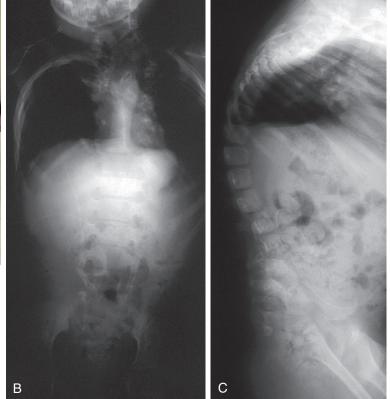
Spina bifida. A, This child with thoracic-level spina bifida has an obvious kyphotic deformity. The scars on her back are from surgical closure of her myelomeningocele. B and C, Anteroposterior and lateral radiographs of the spine demonstrate that kyphosis is secondary to incomplete posterior osseous support.
